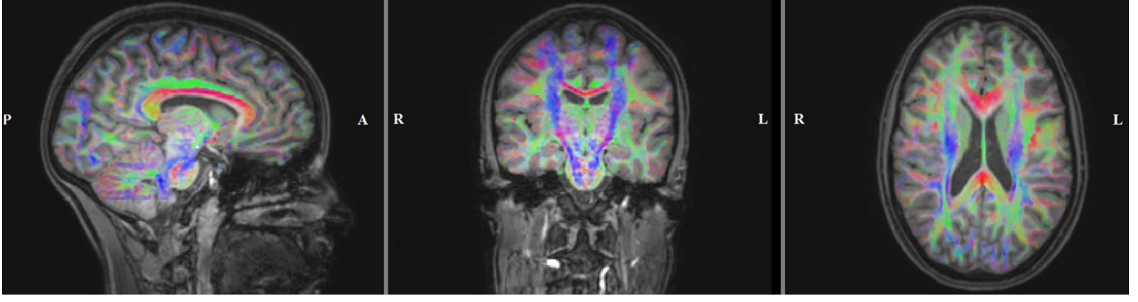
Main fiber directions (largest eigenvalues of diffusion tensors) weighted according to the fractional anisotropy (FA) values for sagittal (left), coronal (middle) and axial (right) slices. The maps are registered and plotted on the T1-MRI. The colors indicate the main fiber orientations: red is left-right, green is anterior-posterior and blue is superior-inferior.
